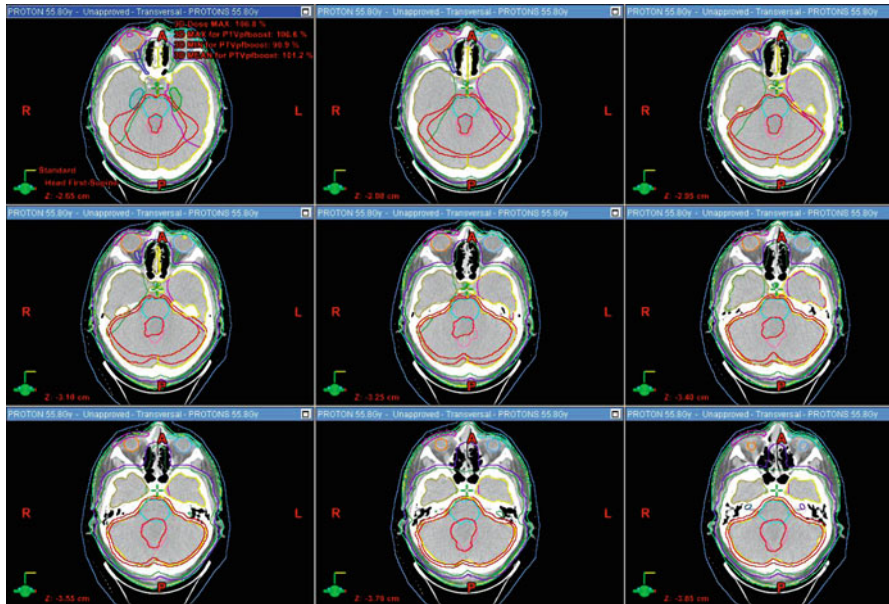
The posterior fossa contours in a series of CT slices. The posterior fossa (inner orange red) is the CTV; a margin on 3–5 mm is added to the CTV to create the PTV (outer orange red). The tumor bed is outlined in red
